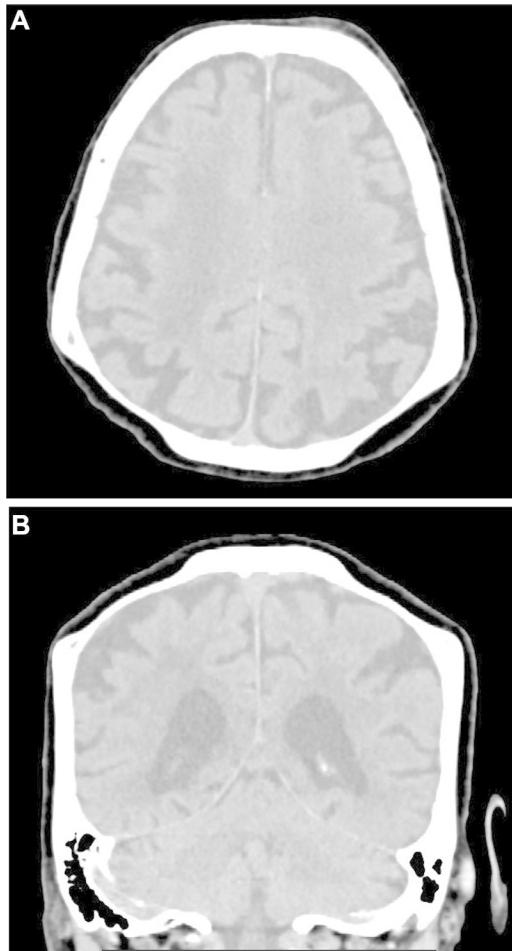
Axial (A) and coronal (B) CT head images in soft-tissue window, showing the overlying scalp and soft tissues. The scalp is intact with no external defect or hematoma, confirming that the depressions are confined to the bony calvarium. There is no evidence of soft tissue mass or swelling over the thinned parietal regions.
